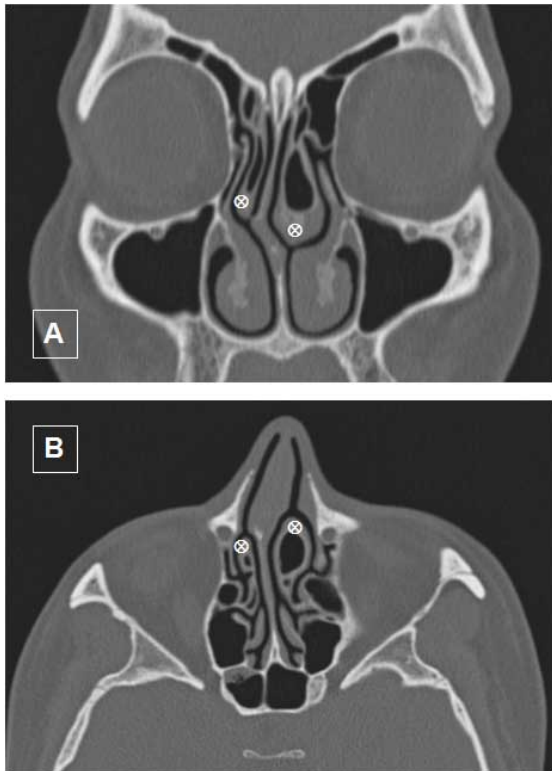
Bilateral CB (⊕) right dominant MNC, SD towards left, equally sized INC. A: Coronal CT image, B: Axial CT image. CB: concha bullosa, SD: septum deviation, MNC: middle nasal concha, INC: inferior nasal concha.
